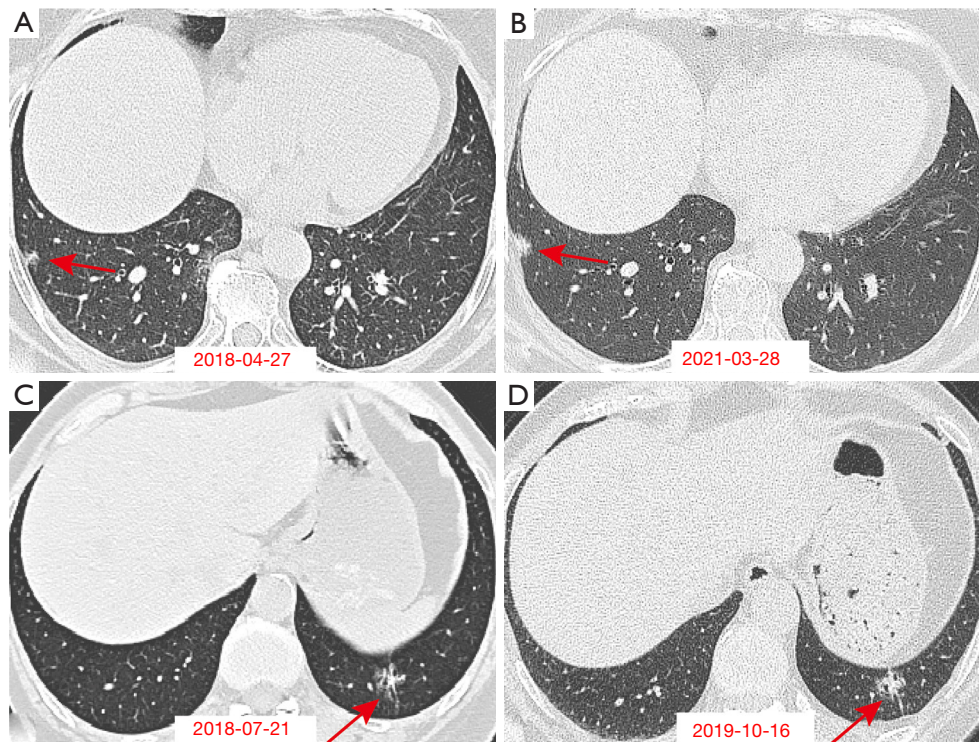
Axial CT images show the change in ciliated muconodular papillary tumor during follow-up. (A,B) A 68-year-old female with a ciliated muconodular papillary tumor (red arrow) in the right lower lobe. Sequential images show that the nodule increased in size and solid components enlarged. (C,D) A 63-year-old female with a ciliated muconodular papillary tumor (red arrow) in the left lower lobe. Sequential images show that solid components of the nodule were enlarged. CT, computed tomography.
